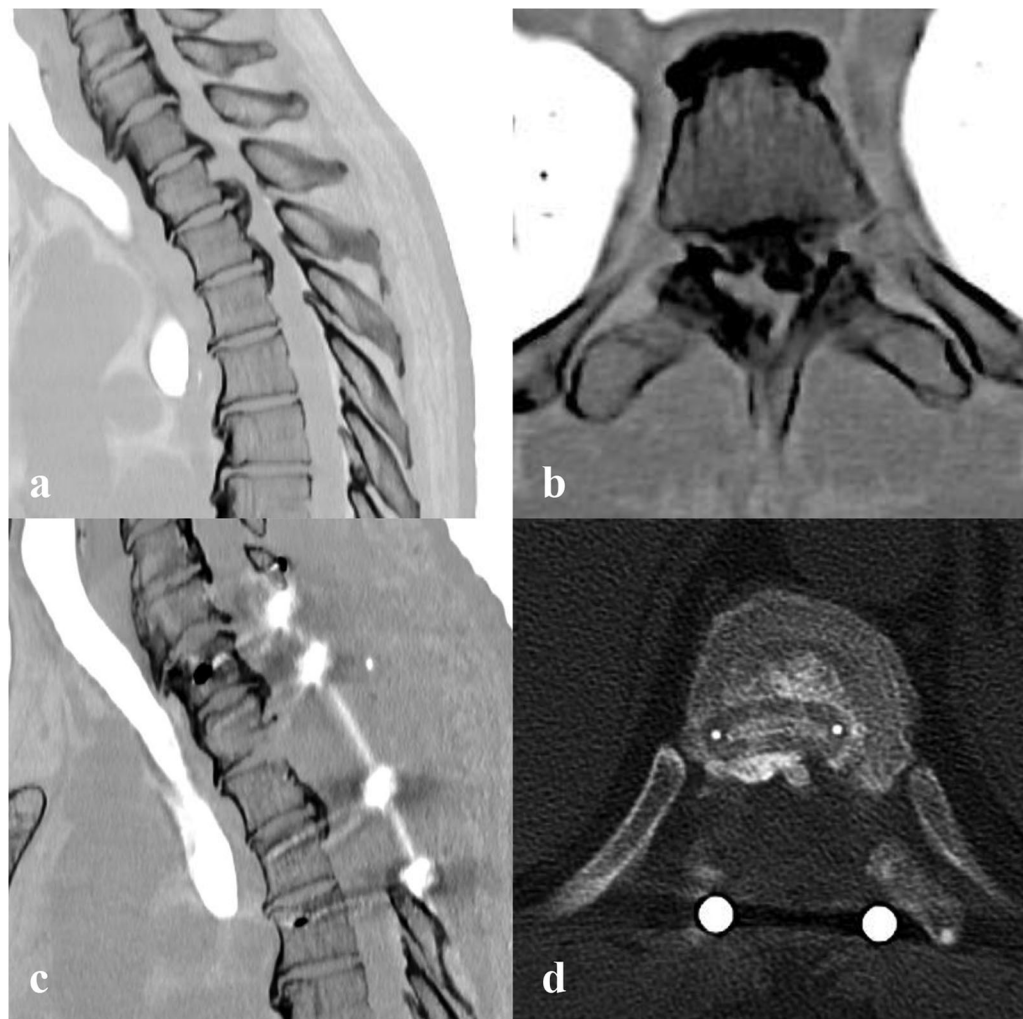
Radiographs showing a 50-year-old female with severe TOPLL (a); axial CT scans showed severe ossification in T2/3 segments (b); After decompression surgery with piezosurgery technique, the ossification was removed (c); and the intraspinal area was significantly enlarged (d).
